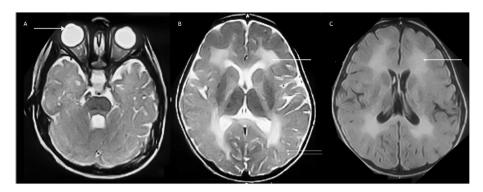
Hypomyelination with congenital cataracts (HCC): Axial T2 image (A) shows bilateral cataracts and mild diffuse infratentorial and temporal hypomyelination. Image (B) shows confluent more T2 hyperintense white matter changes in periventricular and deep distribution against a background of diffuse hypomyelination. FLAIR axial (C) better delineates the differential involvement of white matter (white arrow).
